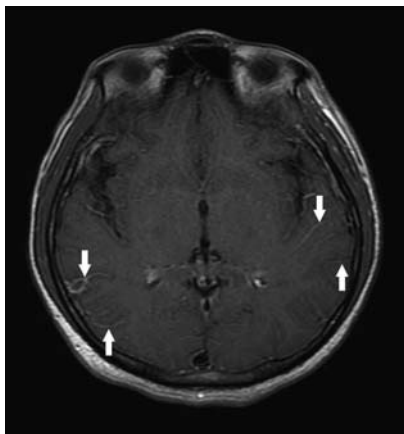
First brain MRI scan of the patient. T1-weighted MRI image with contrast showing diffuse enhancement of vascularities (arrows) along cerebral sulci.
